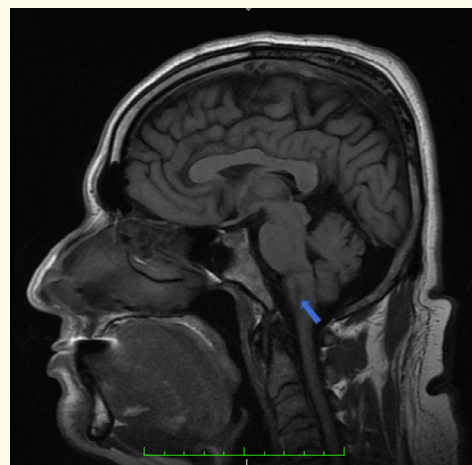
MRI of the skull in the sagittal plane, in T1- weighted, showing zona hypointense oval medulla area (blue arrow).
